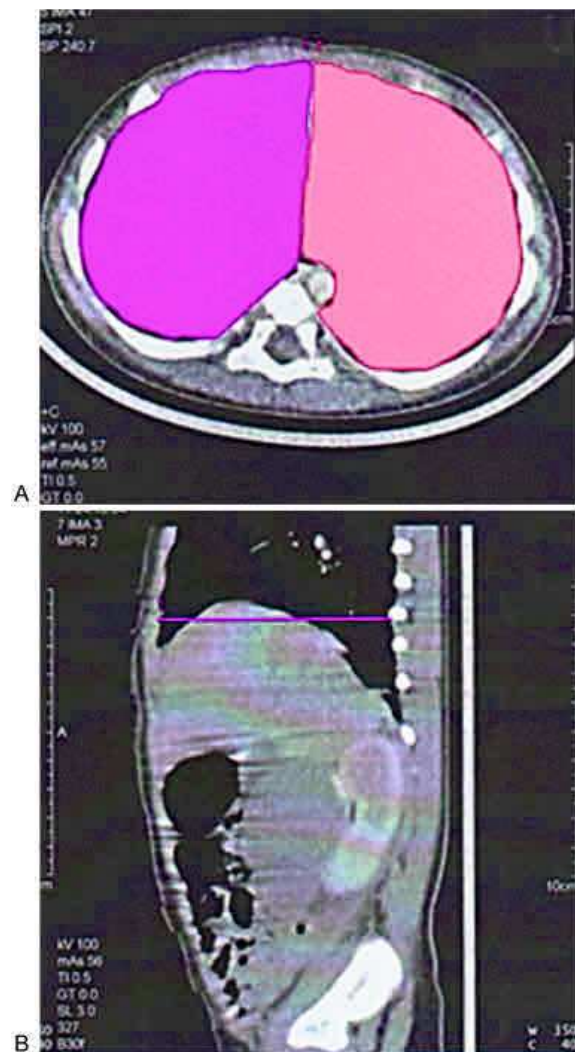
(a, 1b) Method 1: 2D diaphragmatic surface estimation using a CT cross-sectional imaging; (1a) transverse section at the level of the diaphragmatic area; (1b) sagittal view.
